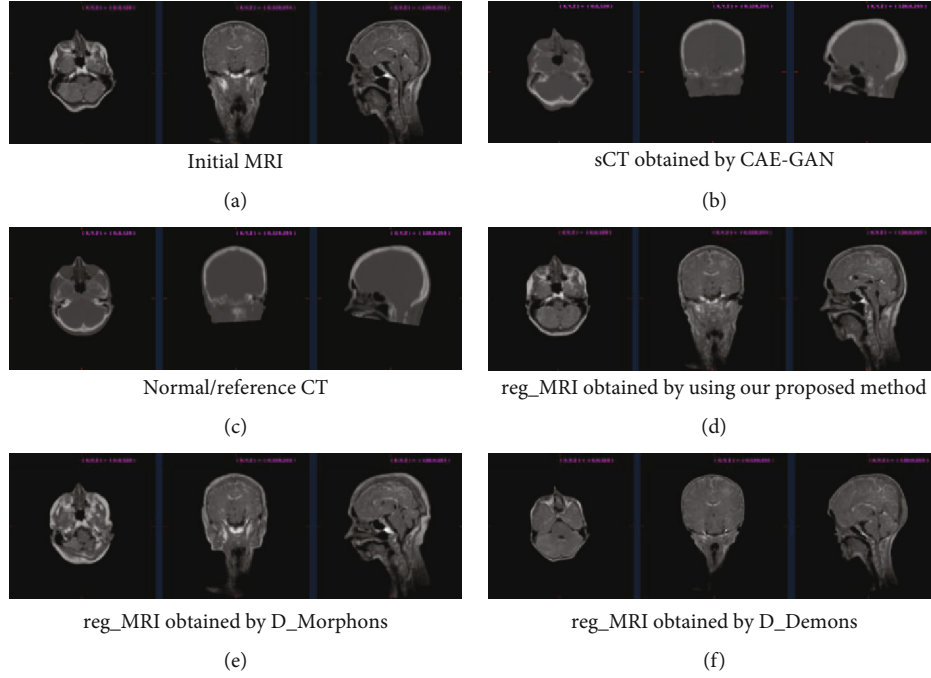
Results of image registration and completion on subject 1. (a) is the initial contaminated MRI, (b) is the synthetic CT as an intermediary, (c) is the normal CT as guidance and reference, and (d)–(f) are registered MRI obtained by using different registration methods. Each slice image is viewed from three perspectives, transverse, coronal, and sagittal, from left to right. The results demonstrate that the reg\_MRI obtained by our method has a high matching of tissue deformation and spatial location with the reference CT and repairs the abnormal MRI.
